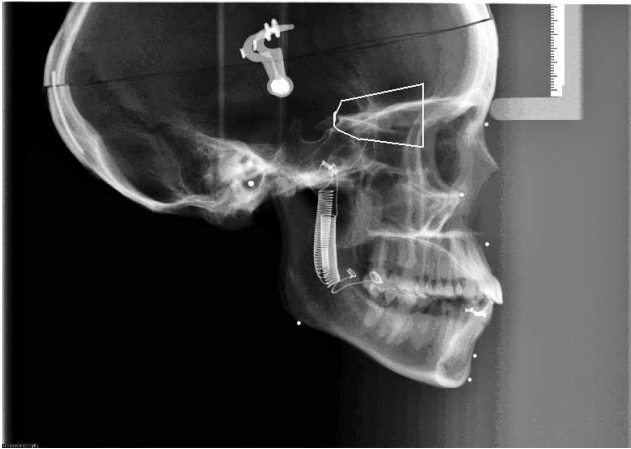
Image of lateral cephalometric radiograph (LCR) with radiopaque markers at cephalometric landmarks and an example of the superimposition region used in this study (white outline).
